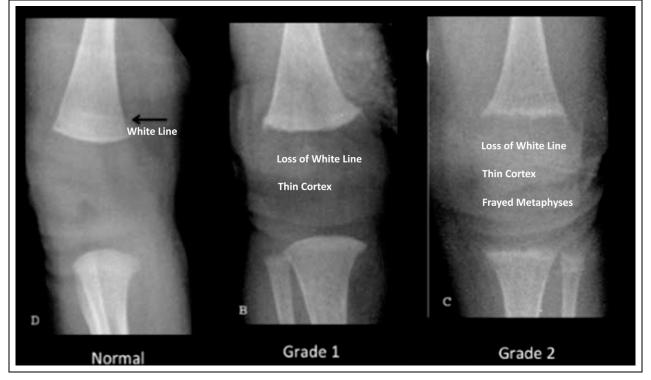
Knee radiographs.
